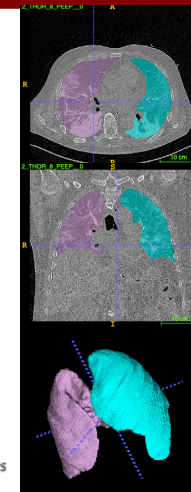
Representative CT scans of COVID-19 patients (axial & coronal view with mask) and the model generated model. A set of control models were generated manually to determine whether the COVID-to-control generator altered scans with normal radiological features.
